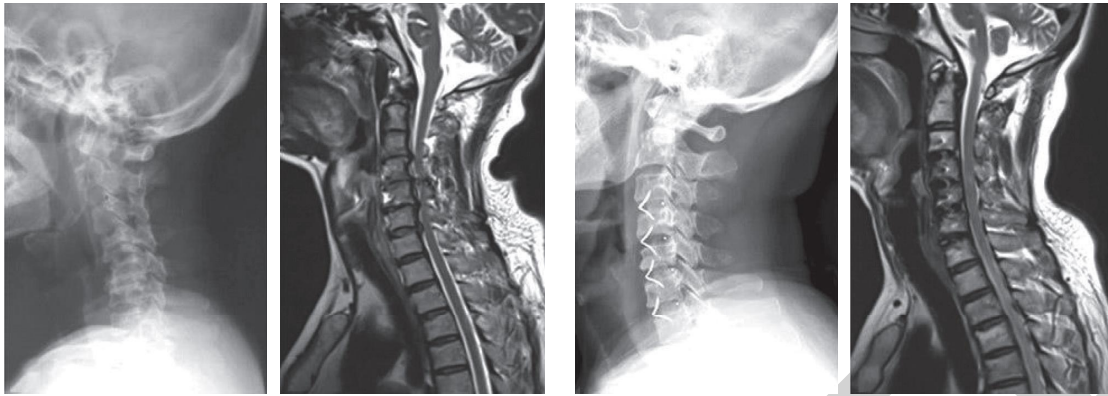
Comparison of preoperative and postoperative MRI and X-ray in anterior cervical decompression and fusion (ACDF) surgery.
